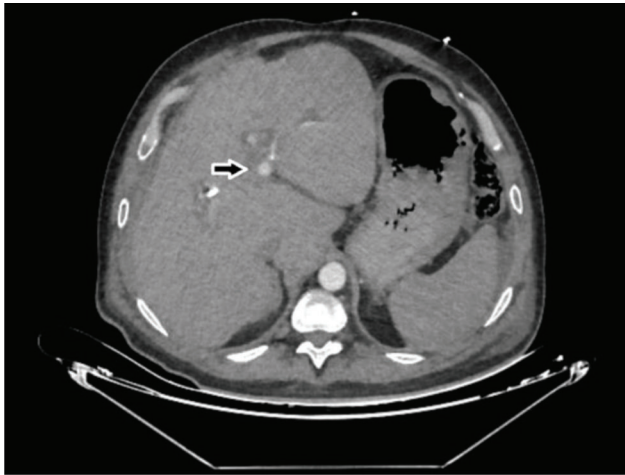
CT angiography shows hepatic artery pseudoaneurysm (arrow).
